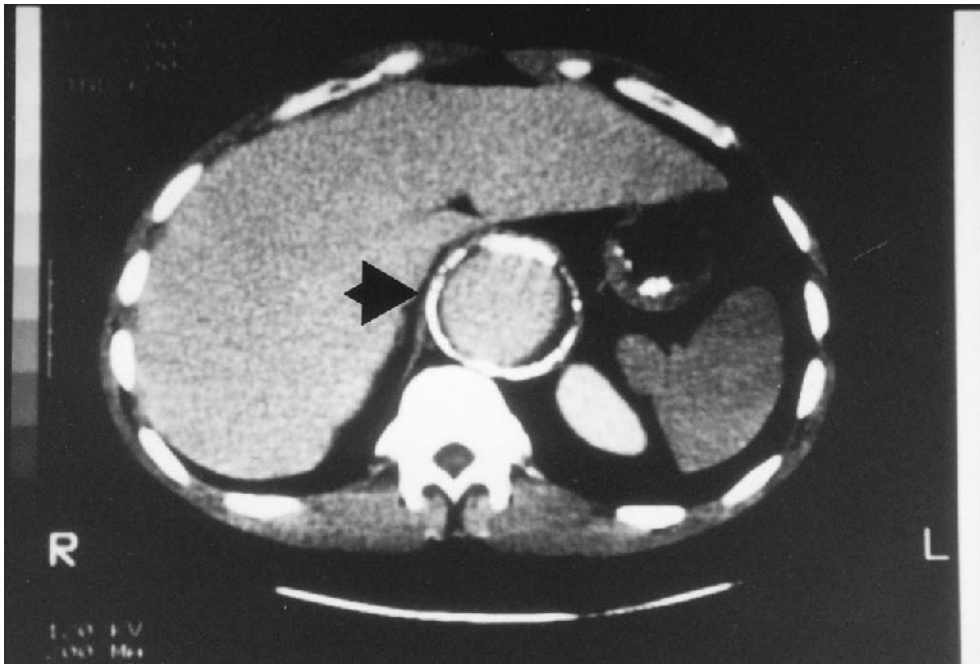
CT scan demonstrating large thoracoabdominal aortic aneurysm extending through the retrohepatic location.
